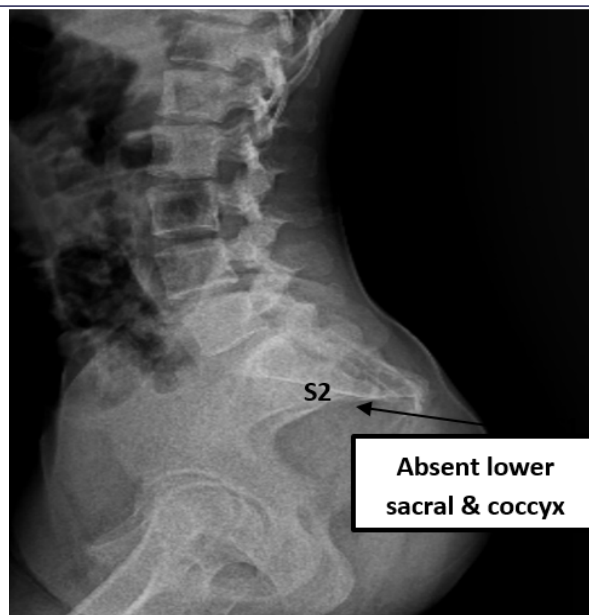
X-ray LS spine AP and Lateral view showing absent visualisation of lower sacral (S3, S4 & S5) vertebrae and coccyx – findings suggestive of partial sacral agenesis.
